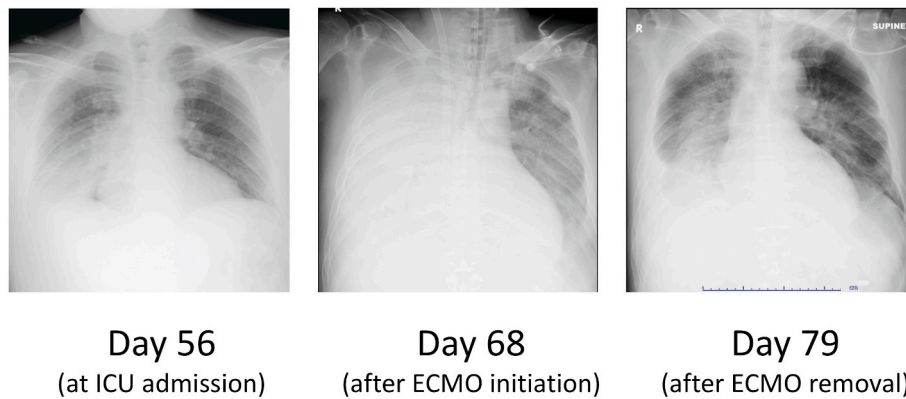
Bilateral pulmonary infiltration improved after antibiotic therapy and ventilation therapy including venovenous extracorporeal membrane oxygenation (Chest radiographs on days 56, 68, and 79). Abbreviations: VV ECMO, venovenous extracorporeal membrane oxygenation; ICU; intensive care unit.
